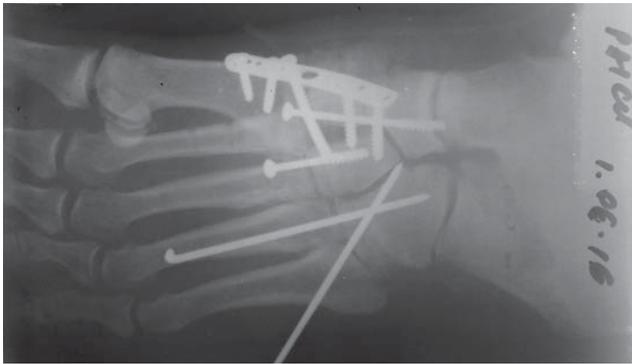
Postoperative X-ray, K-wires inserted.
